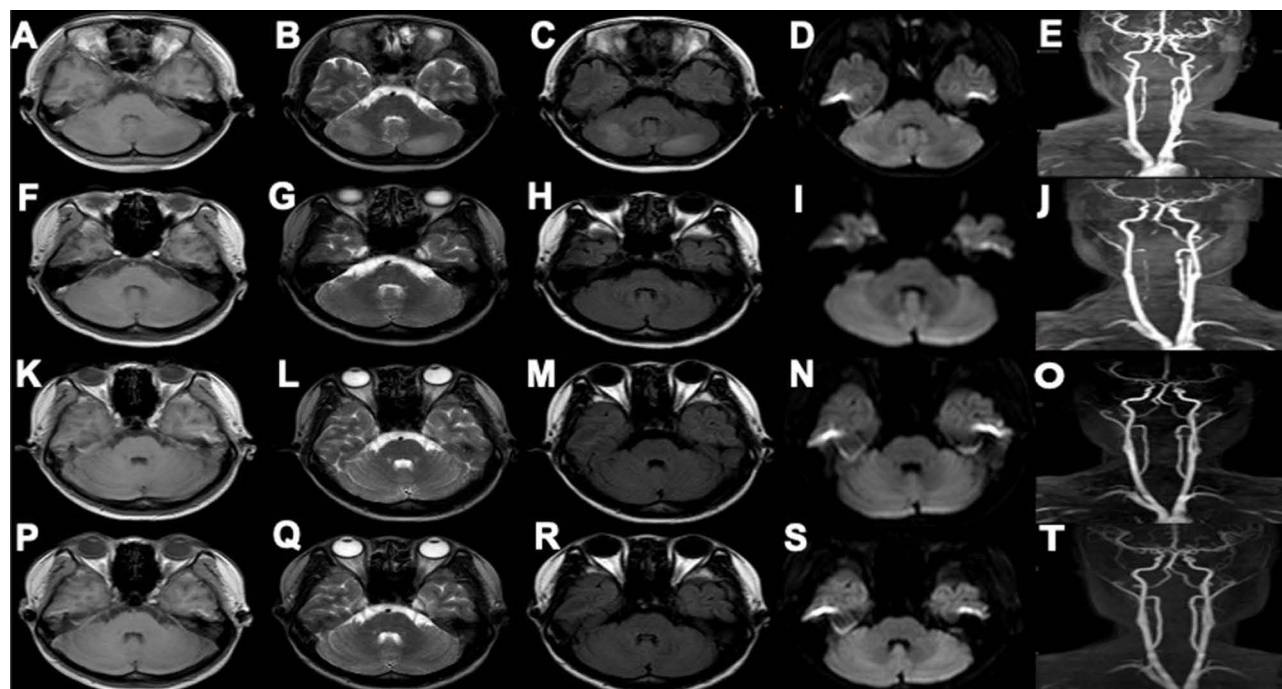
Dynamic evolution of MRI and MRA. The lesions observed on the 2nd day (A–D) were improved on the 14th day (F–I). The vasoconstriction observed on the 2nd day (E) spreads to the whole right vertebral artery, ACA, MCA and PCA on the 14th day (J). As with the improvement in the MRI findings, the constriction of right vertebral artery, ACA, MCA, and PCA was nearly normalized on the 36th day (K–O), except the exacerbating of the aneurysmal dilation in left vertebral artery which improved on the 1 year of onset (P–T).
